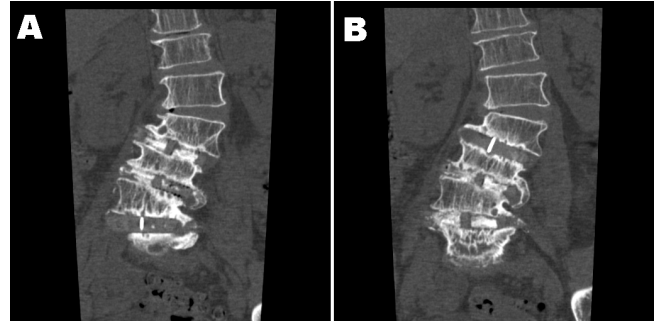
Coronal CT Scan 36 months postoperatively demonstrating bony fusion at L2/L3 (A) and at L3/L5 (B).
